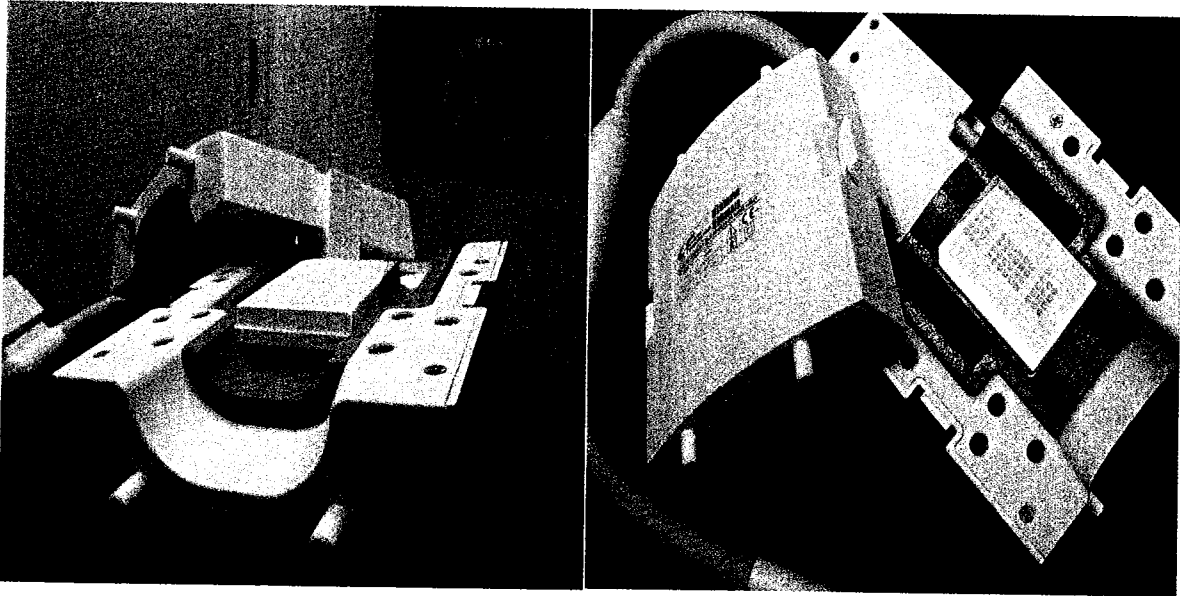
Gel samples placed in the wrist coil prior to MR imaging.
